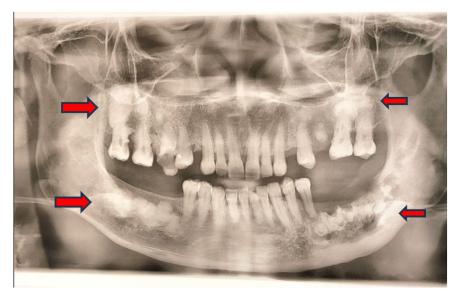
Panoramic radiograph shows multiple irregular radiopaque lesions bilaterally with ill-defined borders in the posterior mandible and also in the posterior maxilla, in the sinister mandibular region, there was cortical destruction, root resorption, and the lesion appeared to extend to the canalis mandibular area
